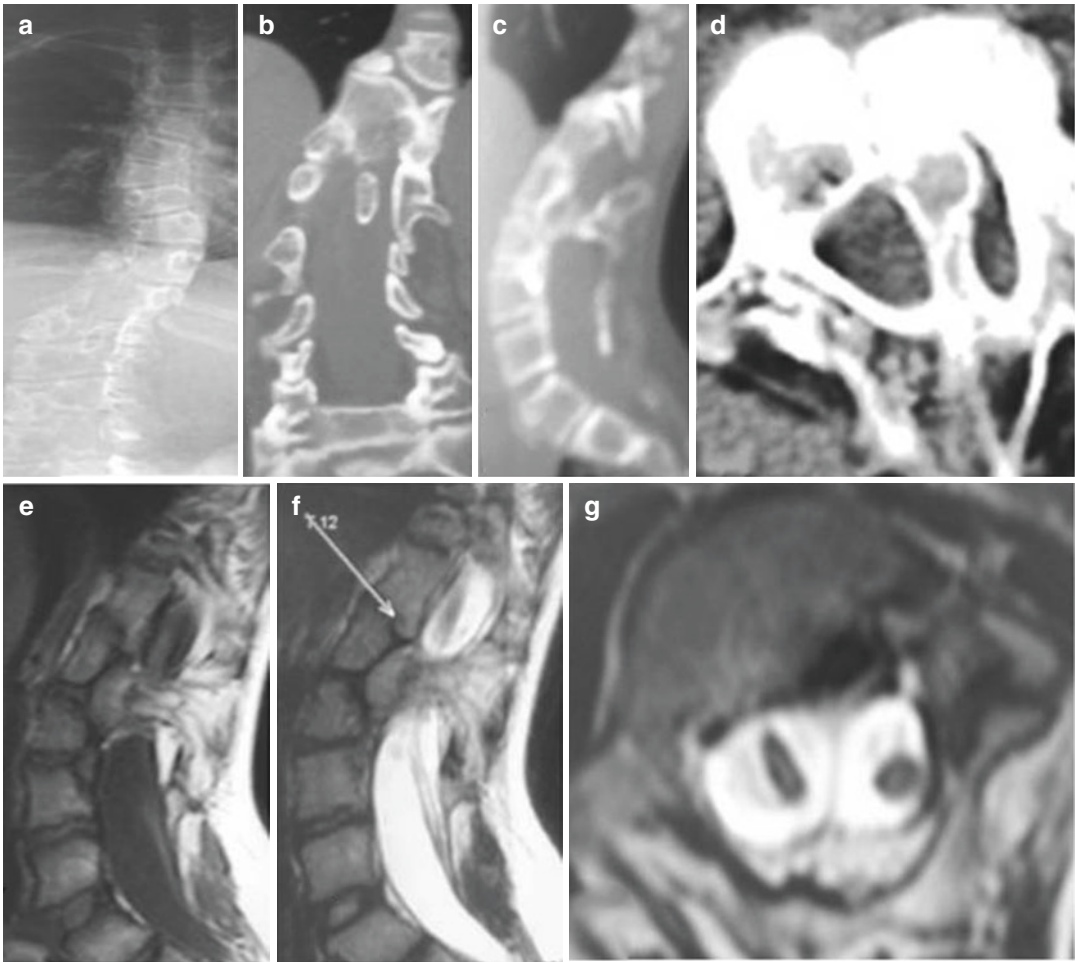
SCM type I in an 11-year-old patient with scoliosis and TCS. Radiological examinations show scoliosis on preoperative radiograph (a), extradural spur on coronal, sagittal and axial CT examinations (b–d), interruption of the cord at the level of lumbar-1 on T1- and T2-weighted sagittal and T2-weighted axial MRI views (e–g). The patient was operated on under general anesthesia and in the prone position. Bone spur after laminectomy
